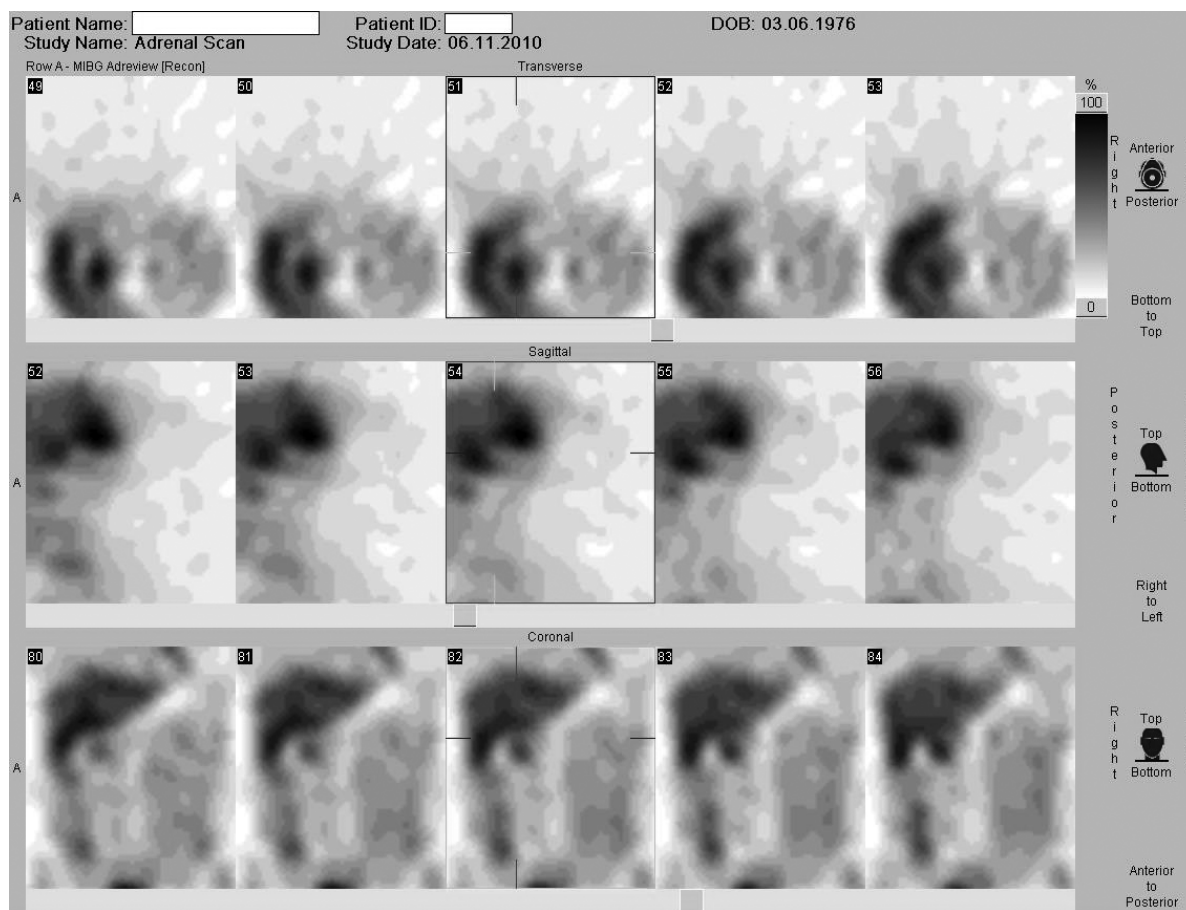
Adrenal gland scintigraphy using ^{123}I -MIBG. Sequence of SPECT images.
